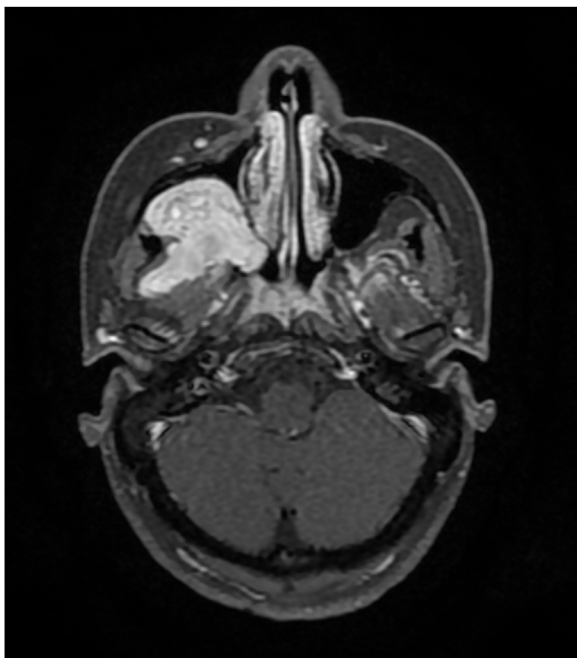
MRI of the face: T1-weighted image showing heterogeneous and considerable enhancement of the tumor after gadolinium administration.
